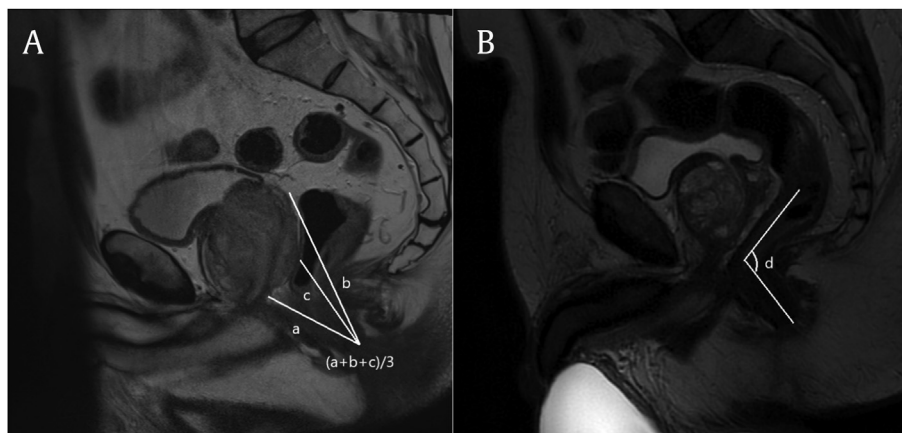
Measurements performed using T2-weighted sagittal multiparametric magnetic resonance imaging (MRI) sequences. Prostate–anus surface distance (PASD) [distance from the anus to the prostate apex (a), to the prostate base (b), and to the median lobe of the prostate c]. (B) anorectal angle (d = angle between the rectal and anal canal axis).
